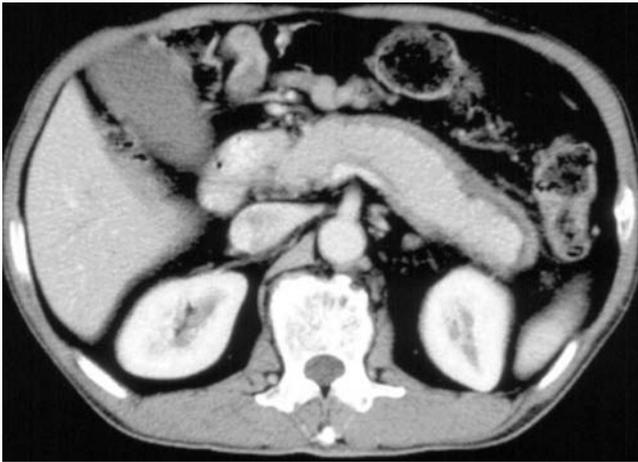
Computed tomography with contrast material of autoimmune pancreatitis, showing swelling and delayed enhancement of parenchymal tissue, resulting in a peripheral low-density area and a capsule-like rim.
